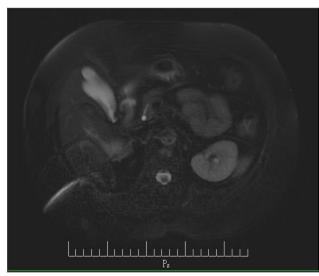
Axial fat saturated T2- weighted MRI image shows the connection between two fundus before common bile duct.
